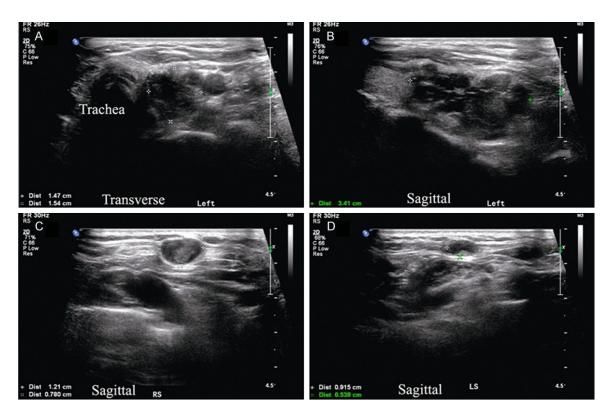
A and B. Ultrasonography of the neck showing one vascularized hypoechoic mass (transverse and sagittal views) in the lower pole of the left thyroid lobe extension to the suprasternal fossa  $(3.41 \times 1.47 \times 1.54$  cm), with vague corticomedullary structure. C. Ultrasonography of the second vascularized hypoechoic nodule (sagittal view) in the right side of the suprasternal fossa  $(1.2 \times 0.8$  cm), without corticomedullary differentiation. D. Ultrasonography of the third vascularized hypoechoic nodule (sagittal view) in the left supraclavicular fossa  $(0.9 \times 0.5$  cm), without corticomedullary differentiation.
